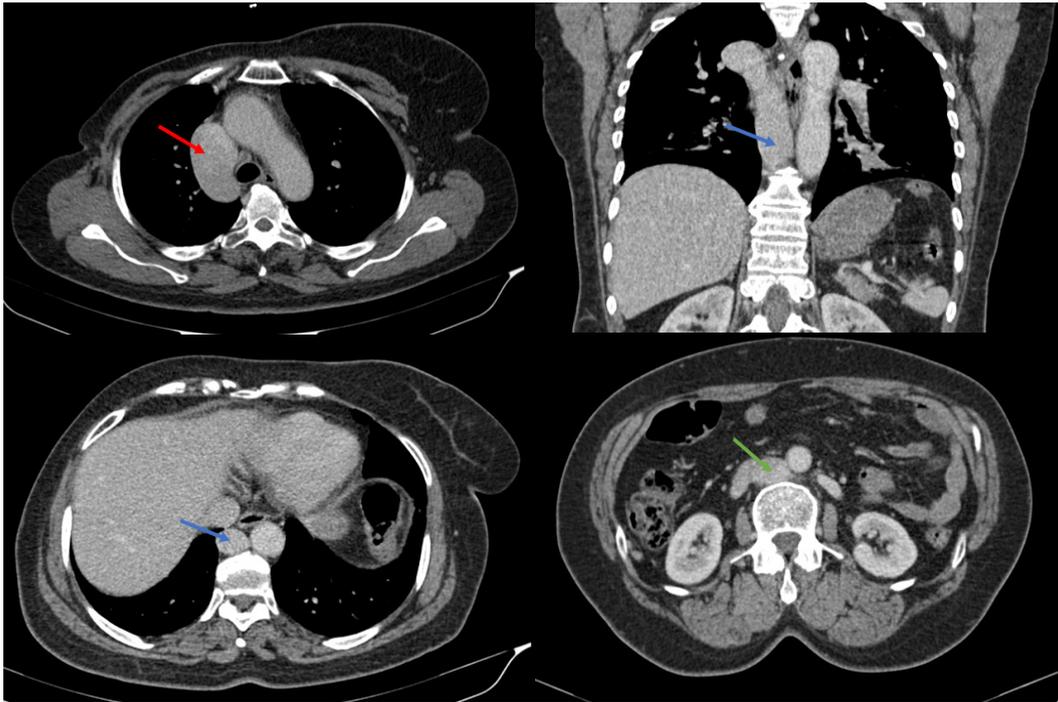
Thoracoabdominal CT scan in axial and sagittal sections: The inferior renal vena cava is interrupted and continues with the azygos vein (blue arrow) which drains downstream into the superior vena cava *via* the azygos arch which is dilated (red arrow). The suprahepatic veins drain directly into the right atrium and the IVC is normal (green arrow).
